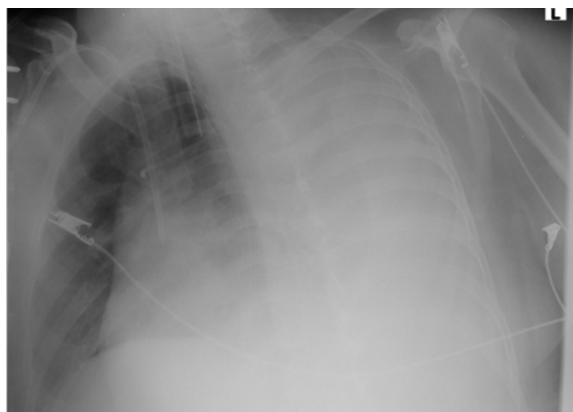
Chest x-ray of the patient showing
